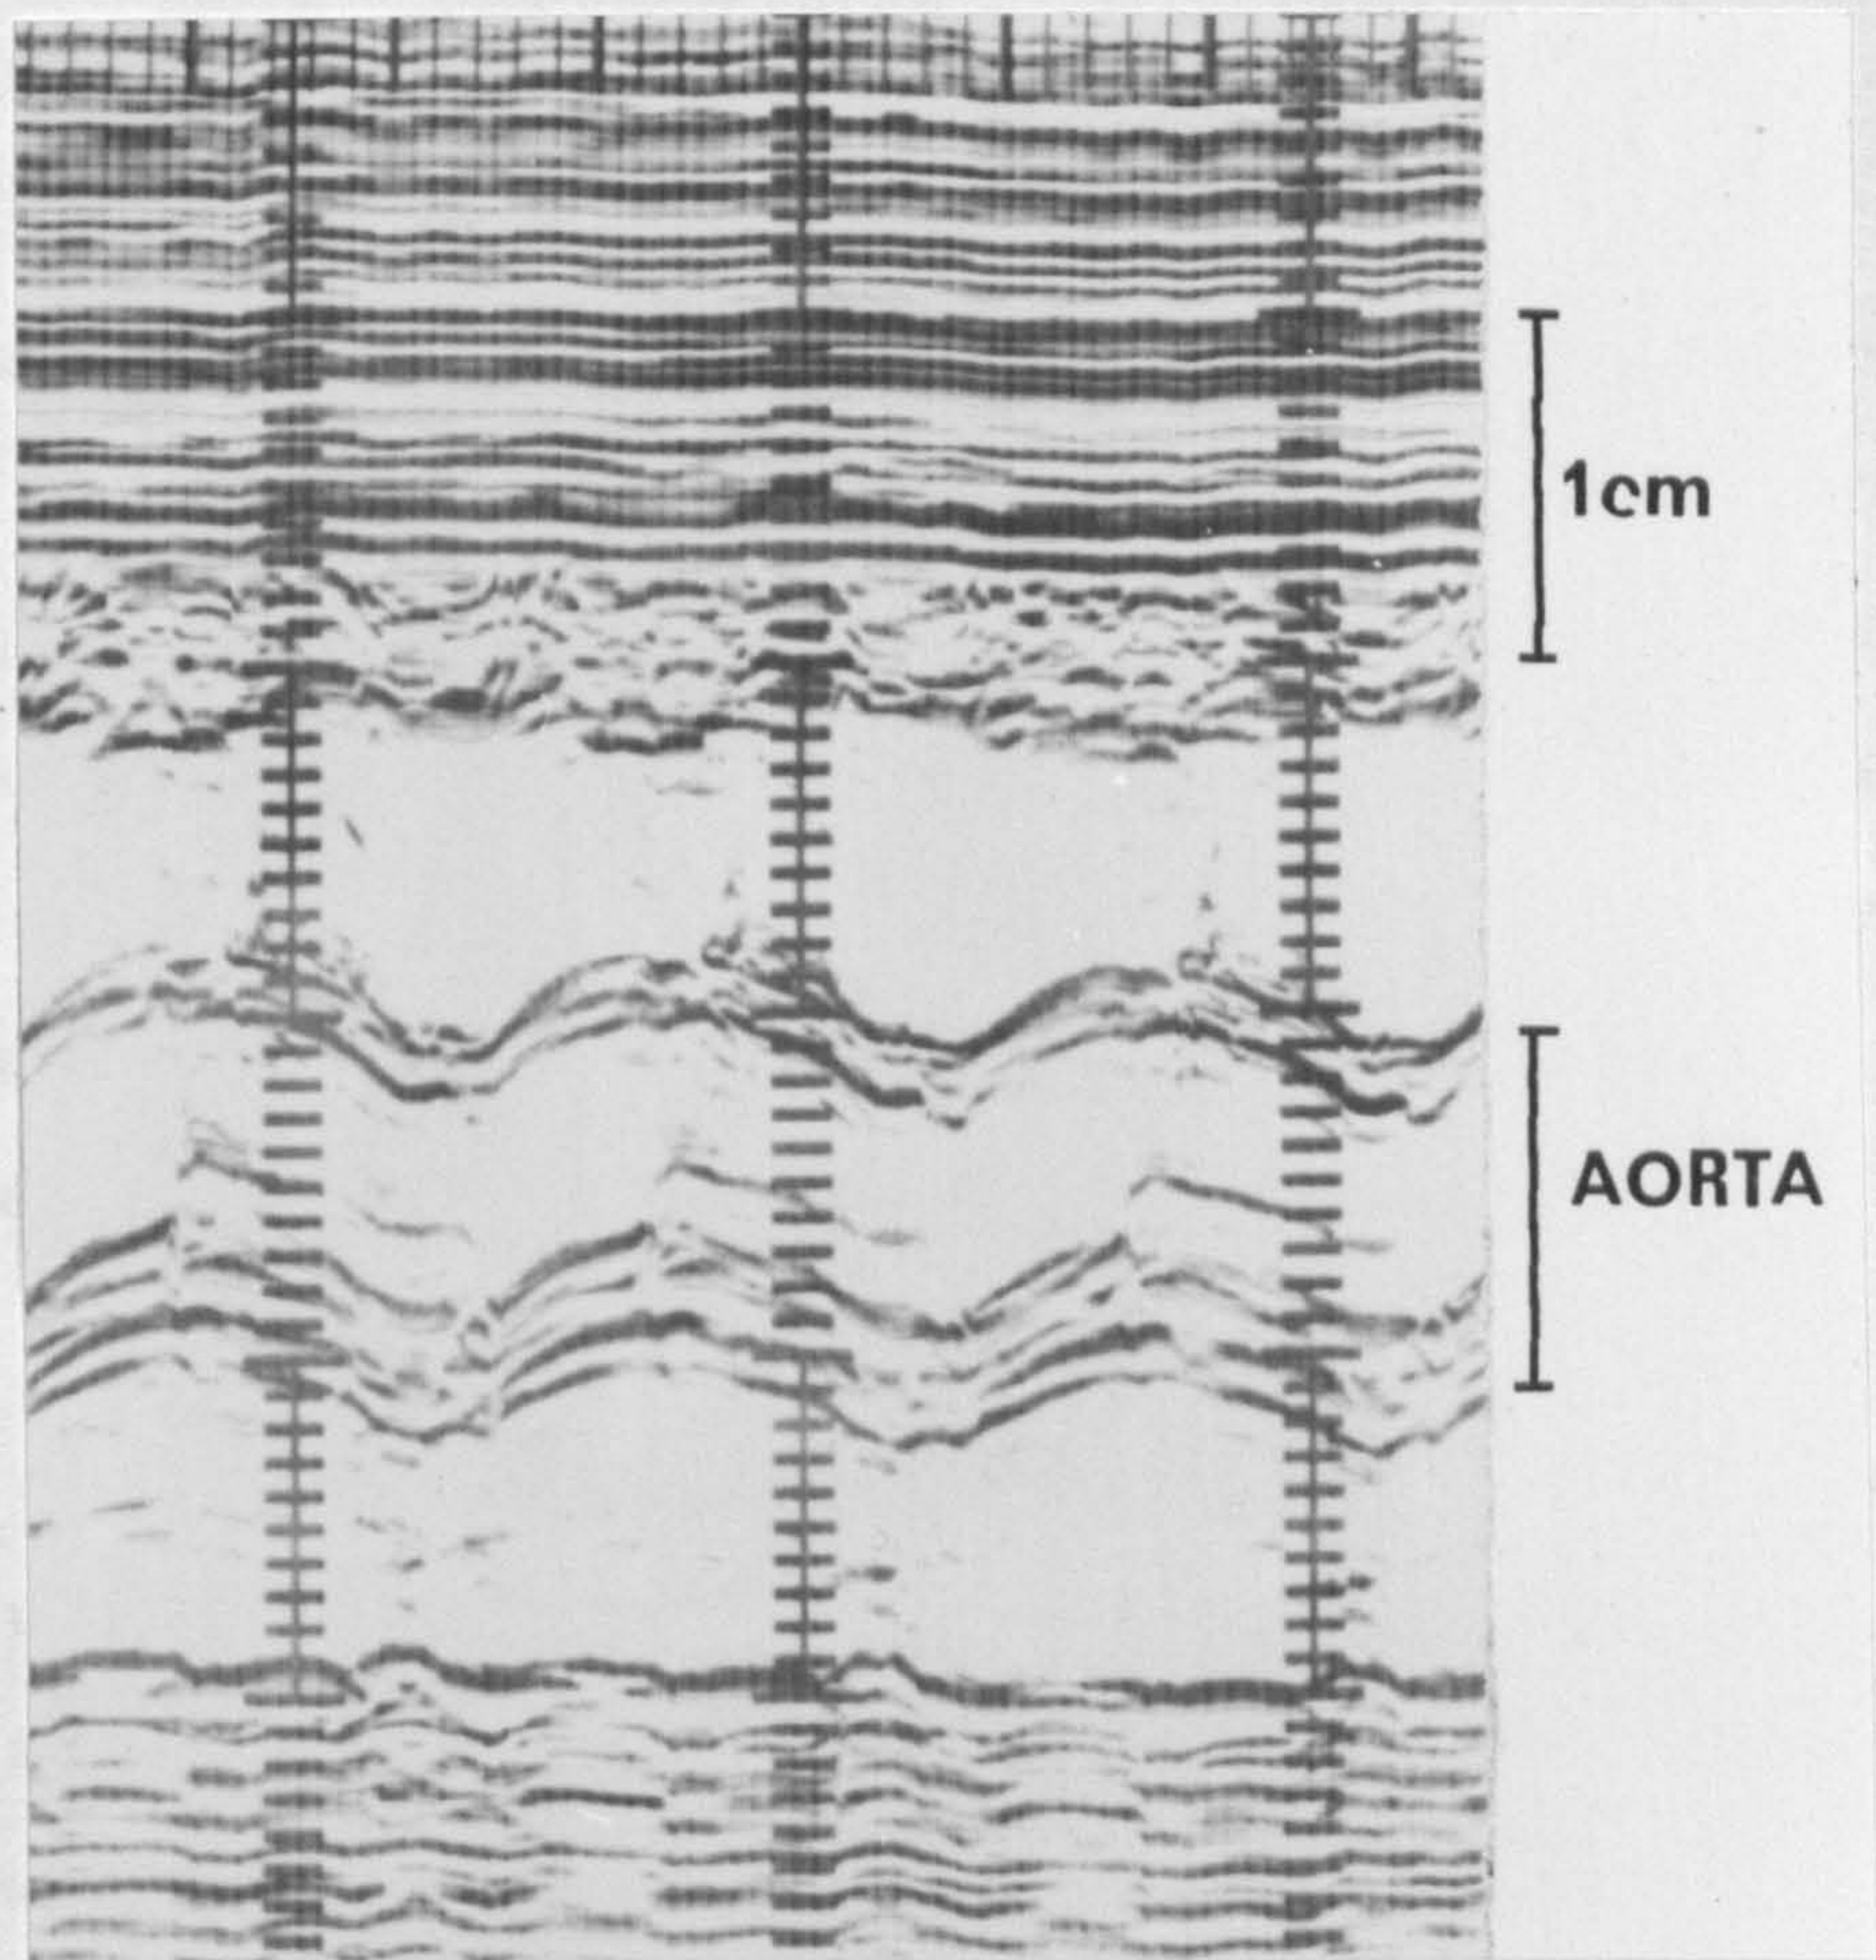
The aortic root can be measured on the M mode echocardiogram. The measurement of 1.1 cms. at 27 weeks gestation when this recording was made is much greater than expected. (See Chapter 8, Figure 8.5).
